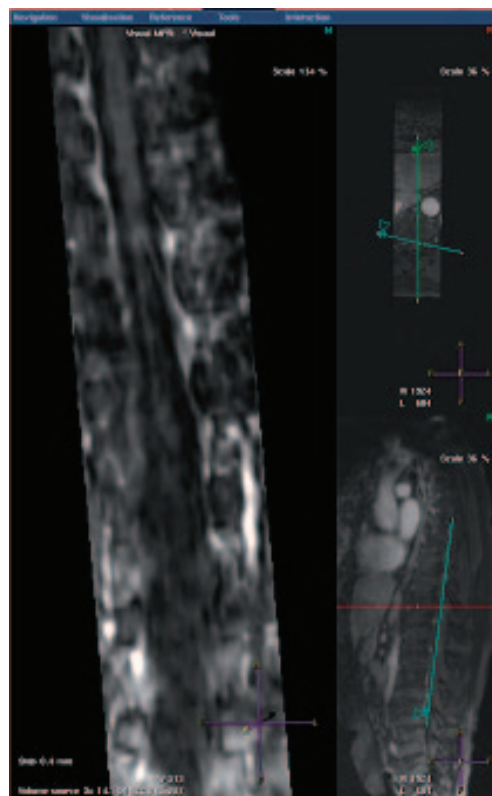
MRI image using Keyhole technique demonstrates the artery of Adamkiewicz and the anterior spinal artery. Because of the high temporal resolution, the artery of Adamkiewicz can be distinguished from the radiculomedullary vein.
